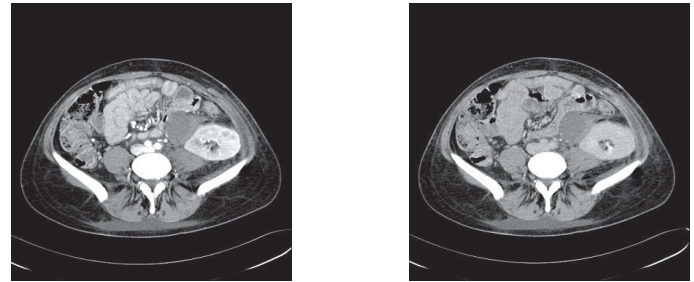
A-B: Abdominal CT revealed perirenal hematoma in renal transplant (Figure A-B).
